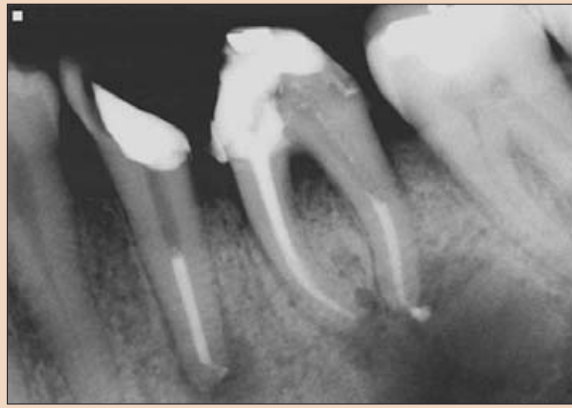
Periapical lesions present associated with lower premolar and molar obturated with Resilon system at completion of endodontic treatment. (Courtesy of Dr. Joseph Maggio).
